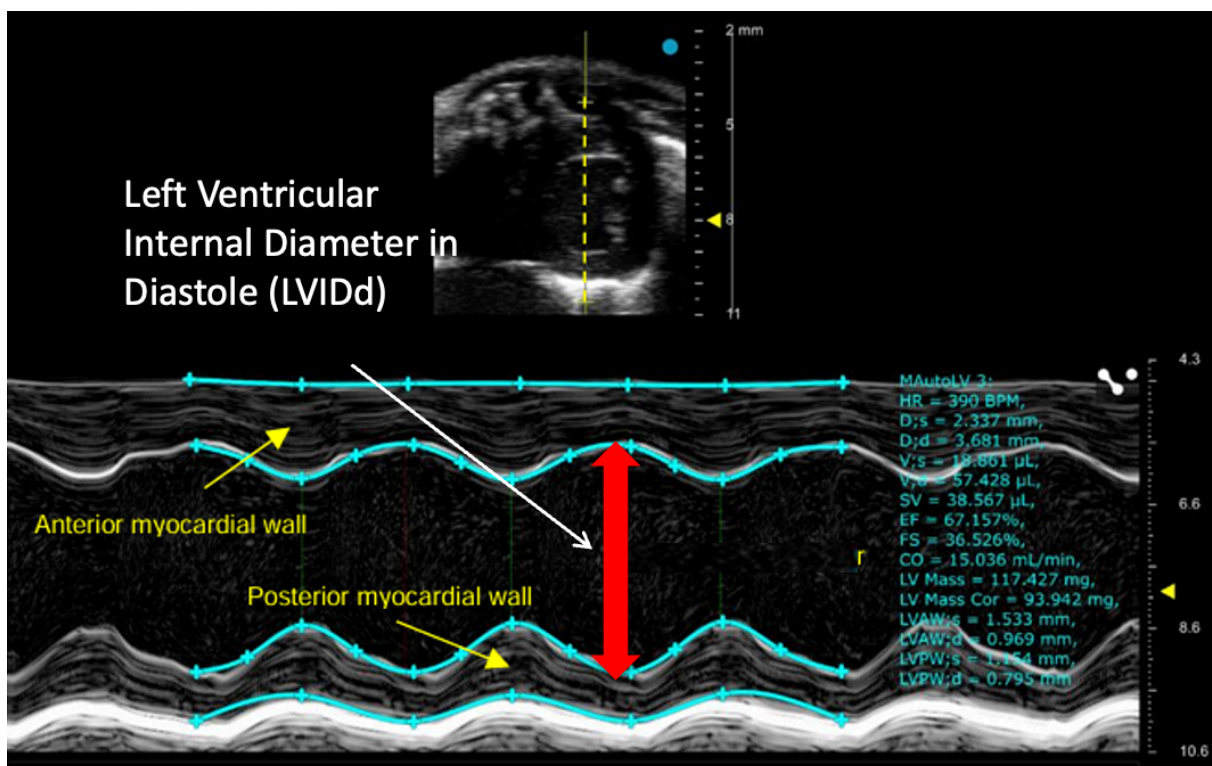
M-mode echocardiography snapshot indicating LVID:d measurements.^[1]
